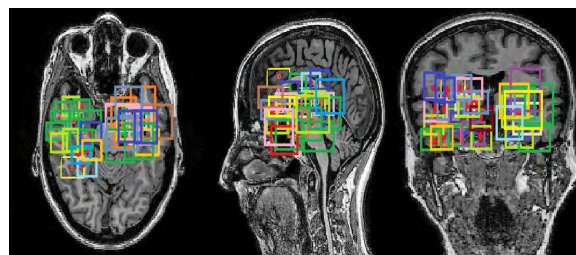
Uniformly distributed random sample points in the vicinity of the hippocampus are used to extract patches. A 2D representation of a 3D 8×8×8 cubic region is selected to generate patches for the local model. The 32×32 patches are extracted from MRI scans and then merged into 32×32×3. These merged patches are used as an input to the local model.
